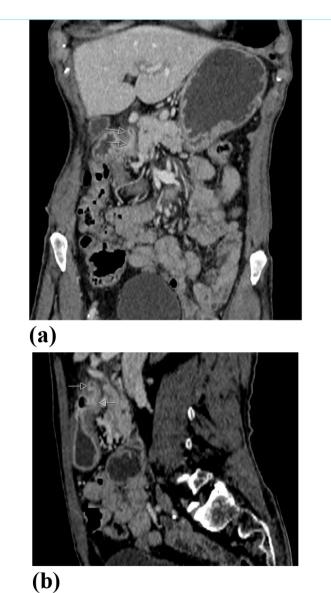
Coronal (a) and sagittal (b) reformatted contrast abdomen computed tomography sections showed a 3x1 cm diverticular filling excess (white arrows) extending from the antrum to the superomedial part of the perigastric region
